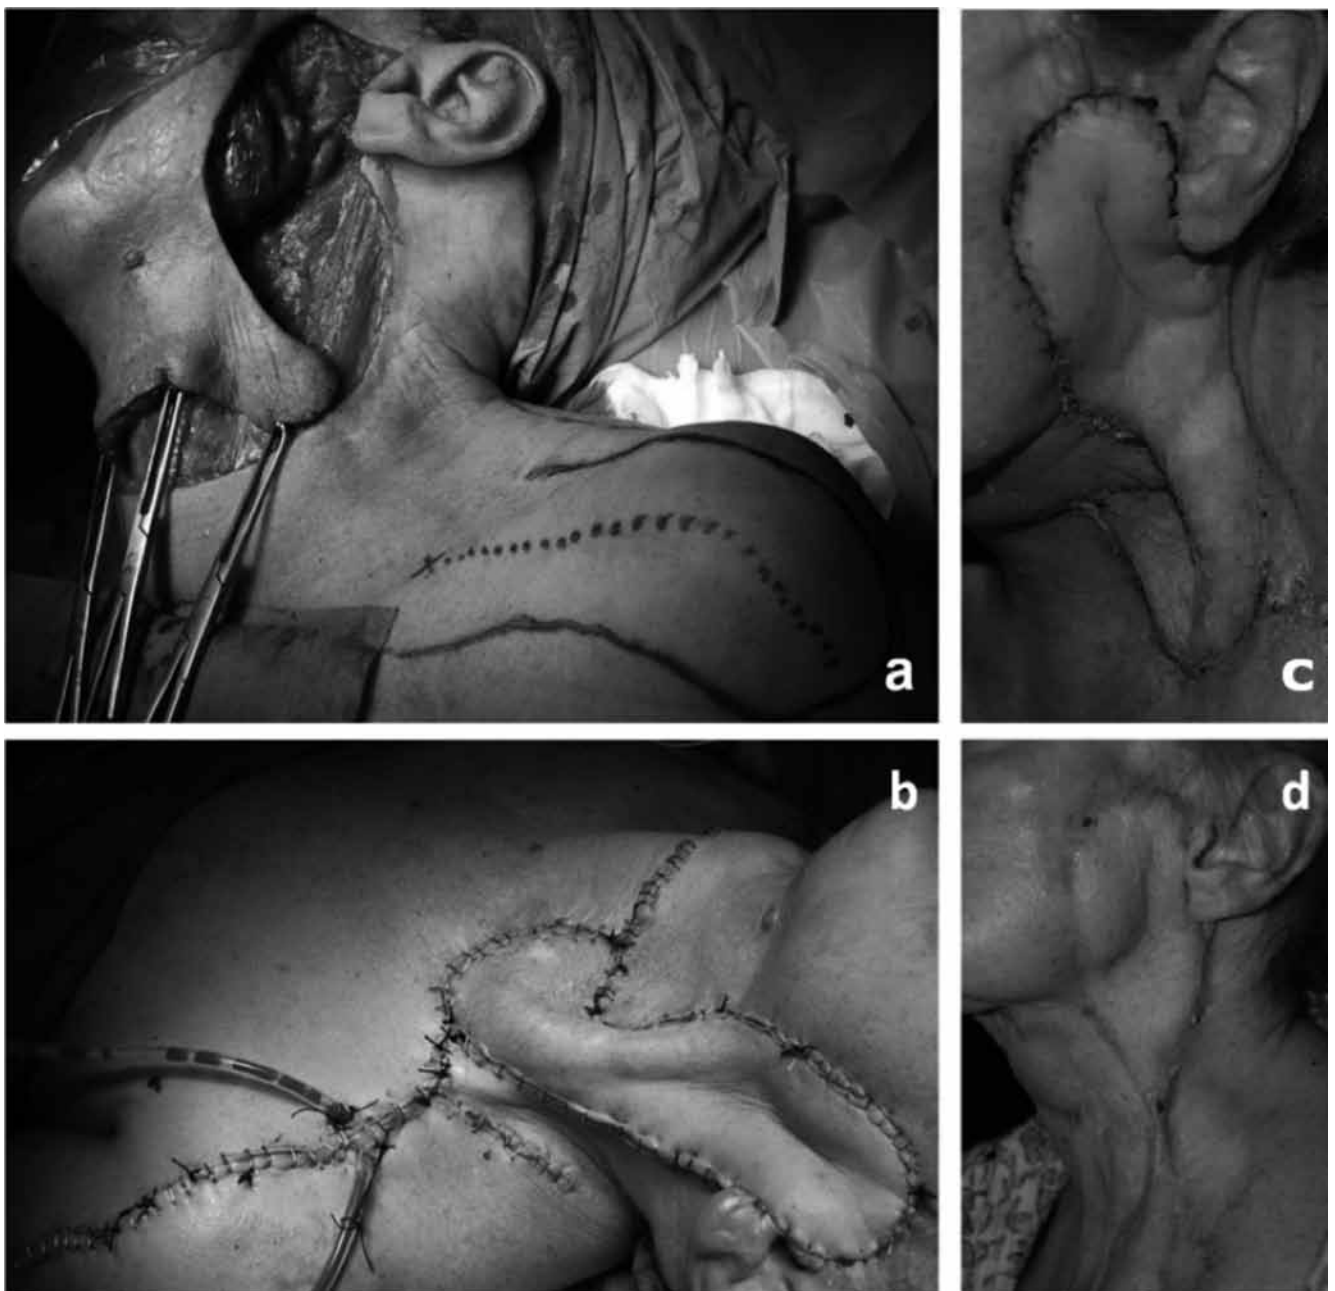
a) Left revision parotidectomy and Doppler mapping of the SCF artery; b) supraclavicular flap harvesting and suturing to reconstruct the facial skin defect; c) post-operative result at 15 days; d) aesthetic result after 6 months.
